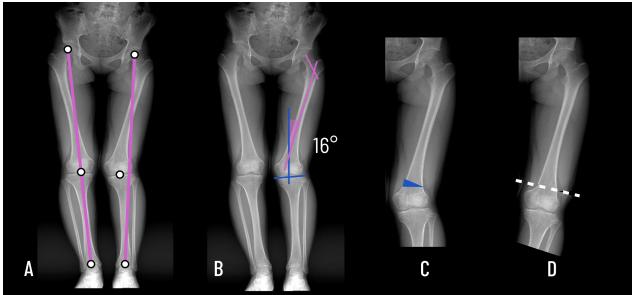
Hip femoral valgus osteotomy. (A) This patient has a left inward-bent knee (valgus) because the center dot is not aligned on the load axis. (B) The malalignment is in the femur, with the correction/malalignment angle. (C) As a result, the blue wedge (that has the same correction angle) will be cut out. (D) The realigned bone after the cut, with the "realignment line" marked. X-ray scans kindly provided by Javier Narbona Cáceres.
